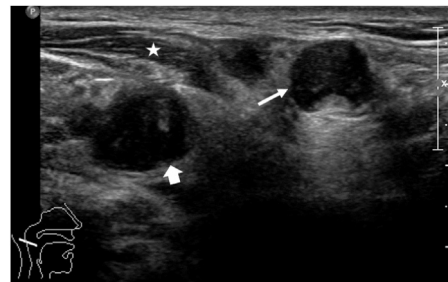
Transverse ultrasonography (US) showed enlarged hypoechoic lymph nodes in the tail of the right parotid gland (arrow) and right neck level II region (arrowhead), which were separated by the sternocleidomastoid muscle (asterisk).
